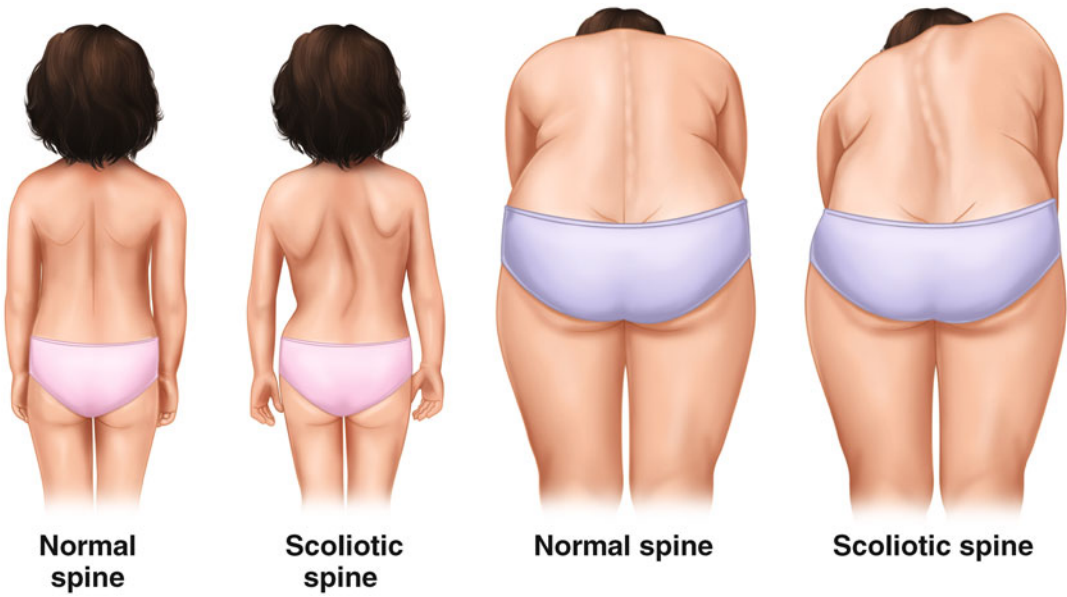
Adam’s forward bend test is a simple way to evaluate visually for asymmetry prior to obtaining radiographs
